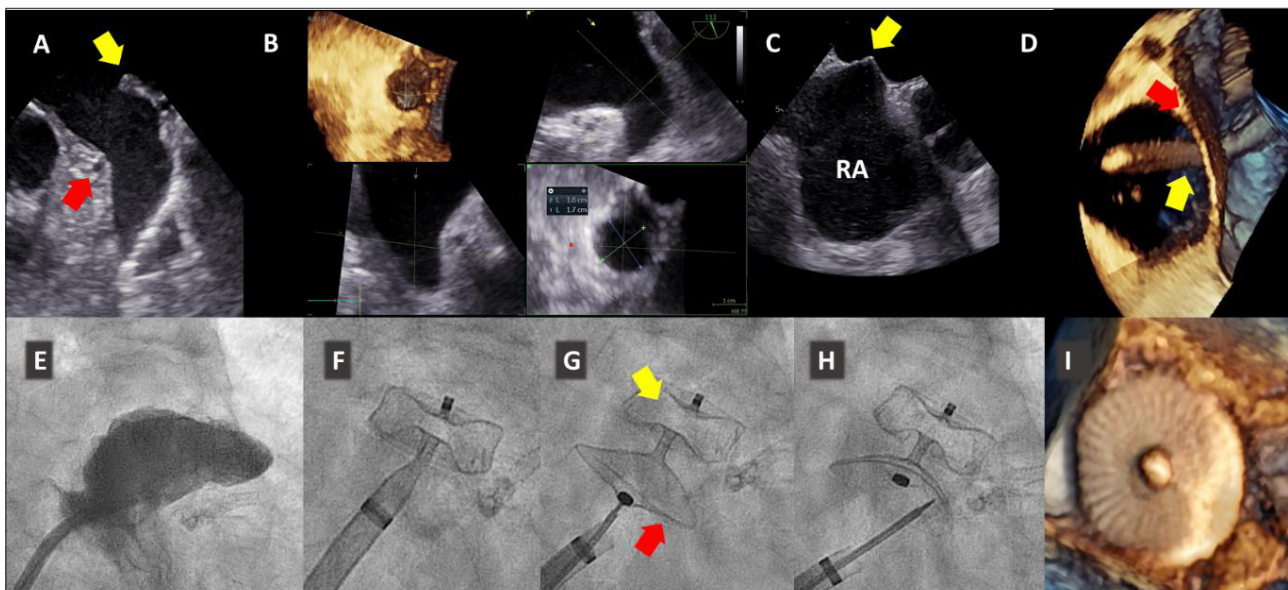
Percutaneous LAAO technique. (A) A TOE view of the LAA, demonstrating the Coumadin/warfarin ridge (yellow arrow) separating the LAA from the left superior pulmonary vein, as well as the circumflex coronary artery (red arrow). The LAA is unilobed and has a windsock morphology. Spontaneous echocardiographic contrast is visible in the LAA lumen. (B) Slice-rendered images, derived from a three-dimensional echocardiographic TOE dataset of the LAA, allowing measurement of the landing zone, which is used for device sizing. (C) Bicaval TOE view of the interatrial septum and RA, with tenting (yellow arrow) of the interatrial septum by the trans-septal needle, prior to trans-septal puncture. (D) Three-dimensional TOE volume-rendered image, showing the delivery sheath (yellow arrow) traversing the interatrial septum (red arrow). (E) Fluoroscopic right anterior oblique 30° cranial 10° view, demonstrating radiographic contrast injection and delineation of the LAA via the delivery sheath. (F) Deployment of the distal lobe of the LAAO device (Amulet). (G) Unsheathing of the proximal disc (red arrow) of the LAAO device, which is still attached to the delivery cable. Separation of the disc and lobe (yellow arrow) has occurred. (H) The LAAO device has been released from the delivery cable, and the deployed lobe (which is mildly compressed and deployed at a right angle to the LAA axis) and disc (which is shaped concavely and occludes the orifice of the LAA) can be seen. (I) Three-dimensional TOE view of the deployed and released LAAO, seen from an LA perspective. (LAAO = left atrial appendage occlusion; TOE = transoesophageal echocardiography; LAA = left atrial appendage; RA = right atrium; LA = left atrium.)
